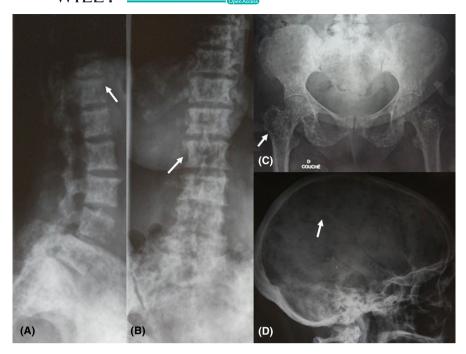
Anteroposterior (A) and lateral view (B) spine radiograph showing diffuse lytic and sclerotic lesions involving vertebral bodies and pedicles (arrows). Pelvis radiograph (C) showing a diffuse mixed bone appearance with expansile lytic lesions of both greater trochanters associated with cortical destruction (arrows). Lateral radiograph of the skull showing multiple lucent and radiodense lesions (D)
